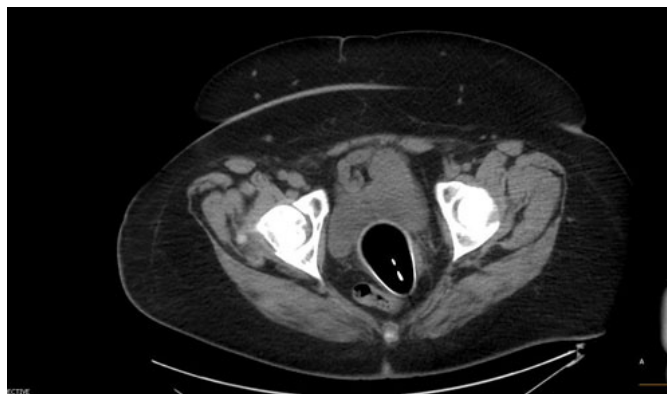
Computed tomography of the abdomen and pelvis shows the foreign body (light bulb) in the vagina, axial view.
